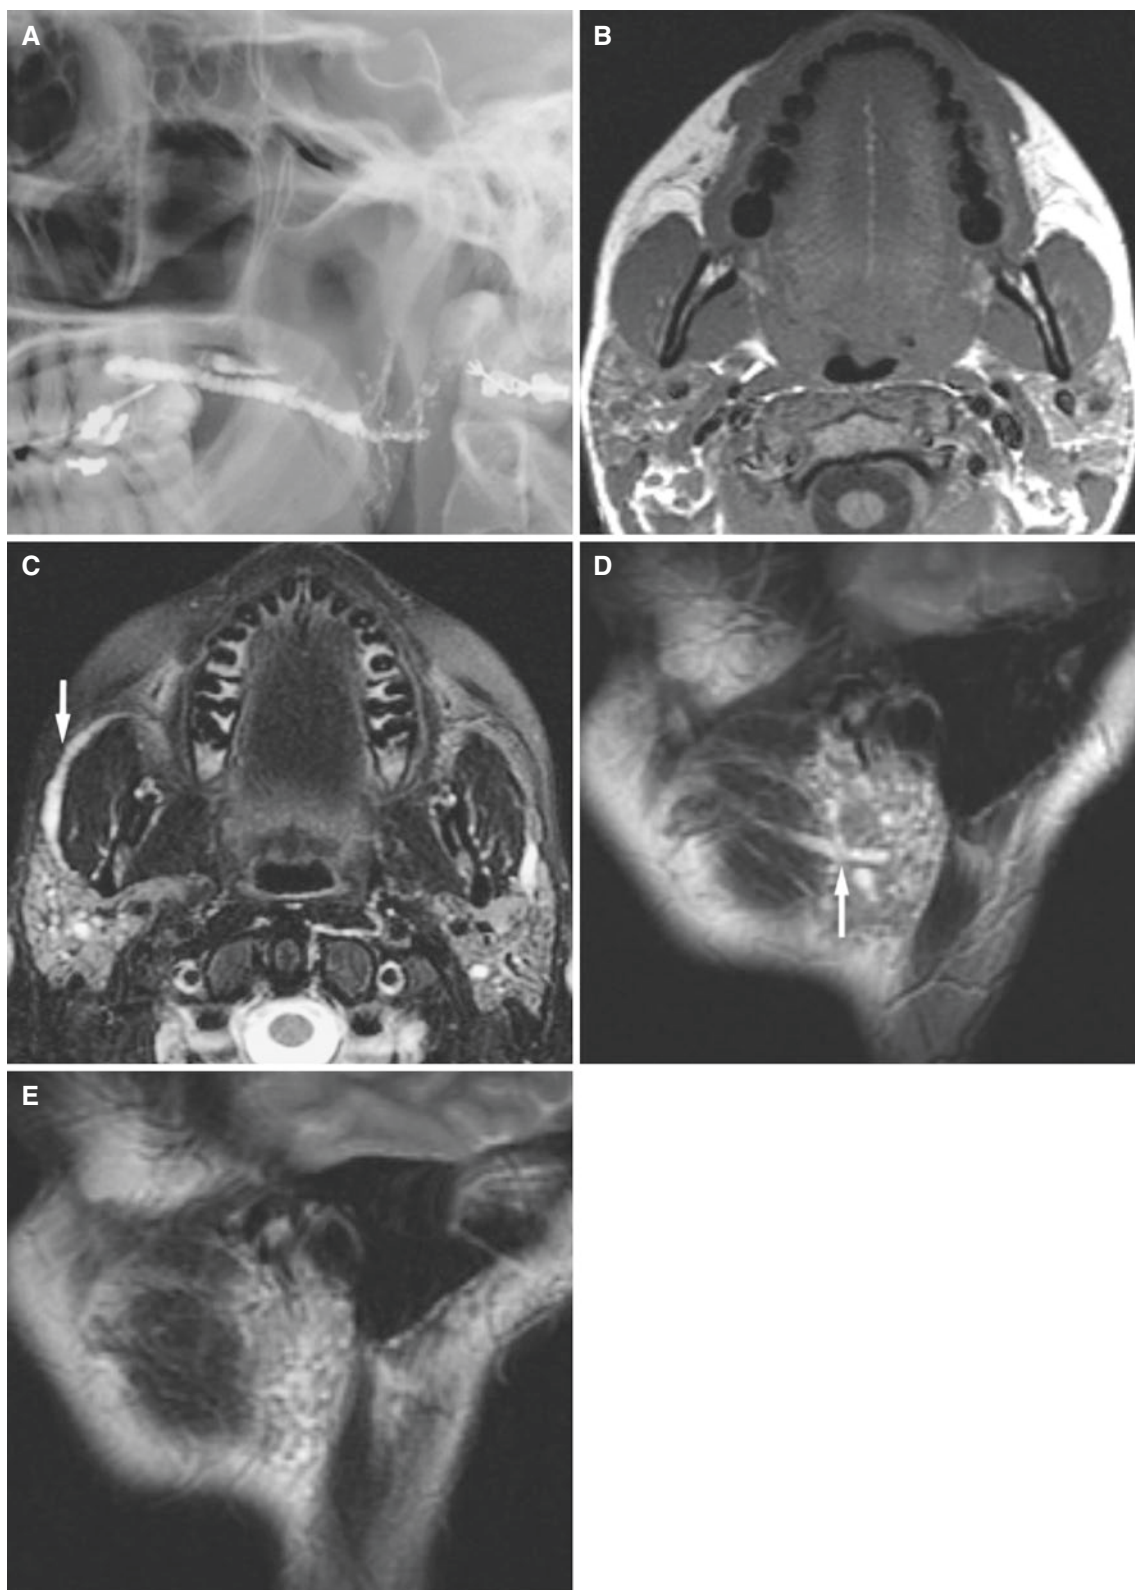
Sjögren's syndrome; 31-year-old female with 2-year history of swelling, mostly of the right parotid gland but also of the left. (A) Conventional sialography shows multiple strictures and dilatations consistent with sialodochitis and poor filling of parenchyma, with some punctate contrast medium collections. (B) T1-weighted MRI shows some swelling of the right parotid gland which has a little less signal
